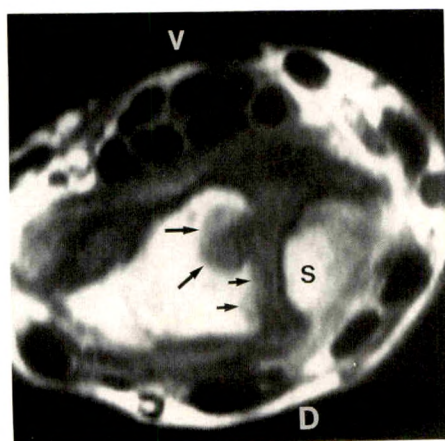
Right wrist. Axial T1-weighted MR image (SE 500/20) of wrist through proximal carpal row shows large erosion of lunate bone (*long arrows*). On conventional radiograph, this appeared to be an entirely intraosseous lesion. Abnormal material with intermediate signal intensity extends from erosion, fills widened scapholunate articulation, and displaces flexor tendons. Interosseous cortical surface of lunate bone is also eroded (*short arrows*). V = volar surface, S = scaphoid bone, D = dorsal surface.
